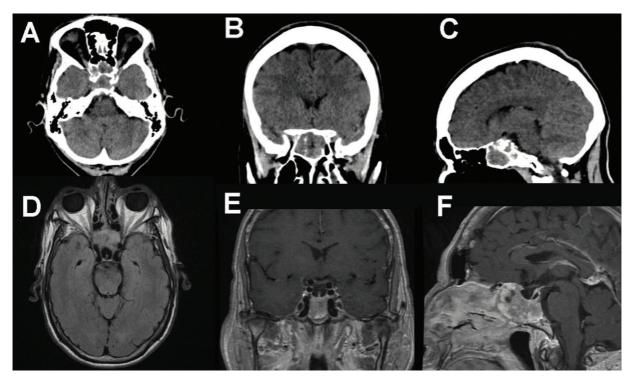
(A–C) Computed tomography in axial, coronal, and sagittal cut, respectively, showing lesion with soft tissue density occupying the sphenoid sinus, with remodeling of the bone walls and partial erosion of the floor of the Turkish sella. There is no apparent intracranial extension. (D–F) Magnetic resonance contrasted in spin echo, fluid-attenuated inversion recovery, and T1, respectively, that evidences solid mass, neoplastic appearance, with few cystic changes, highly cellular and vascularized, with epicenter in the body of the sphenoid. There is no compression of the chiasm.
